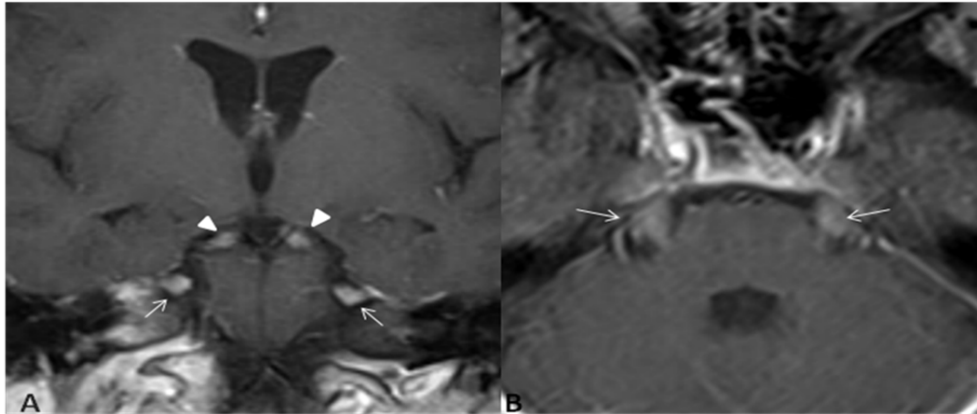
Coronal (A) and axial (B) gadolinium-enhanced T1-weighted MRI views shows enlargement and enhancement of the trigeminal (arrowhead) and oculomotor nerves bilaterally (arrows)
